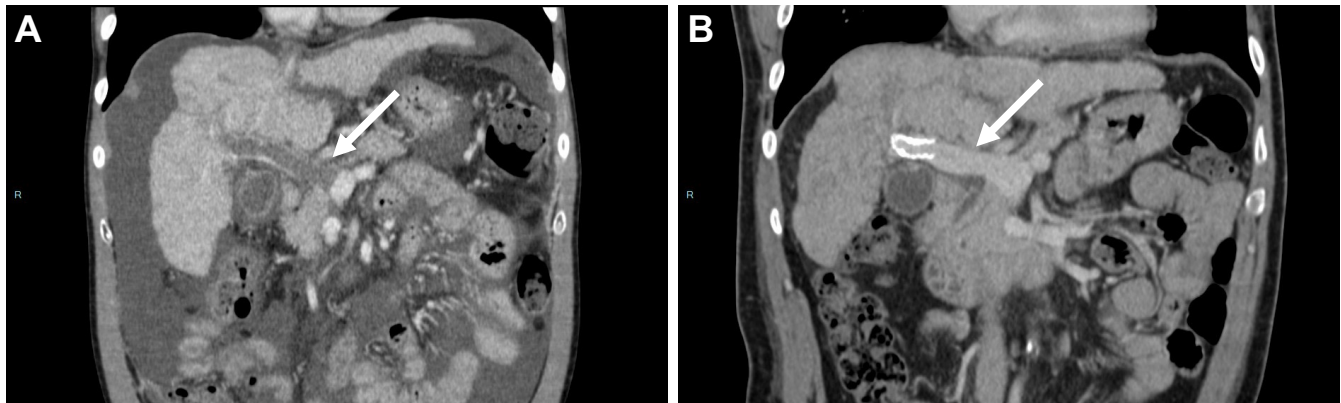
CT scan showing a patient with decompensated cirrhosis and occlusive portal vein thrombosis in whom portal vein recanalization was achieved after TIPS insertion. Patient with (A) occlusive portal vein thrombosis (arrow) despite anticoagulation for 3 months, in whom (B) portal vein recanalization was achieved after TIPS insertion. TIPS, transjugular intrahepatic portosystemic shunt.
